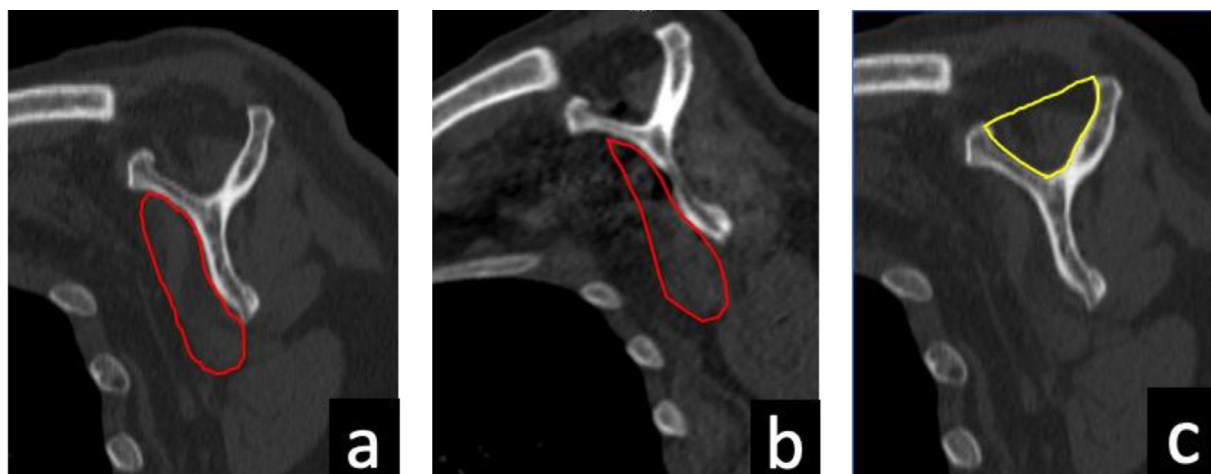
Subscapularis muscle cross-sectional area (SMCSA) and Supraspinatus fossa (SFCSA) were measured in square millimeters in a standardized sagittal-oblique CT slice. Evaluation was performed at the most lateral section on which the scapular spine was still in continuity with the body of the scapula. (a) Preoperative delineation of SMCSA. (b) Postoperative delineation of SMCSA. (c) Delineation of SFCSA.
